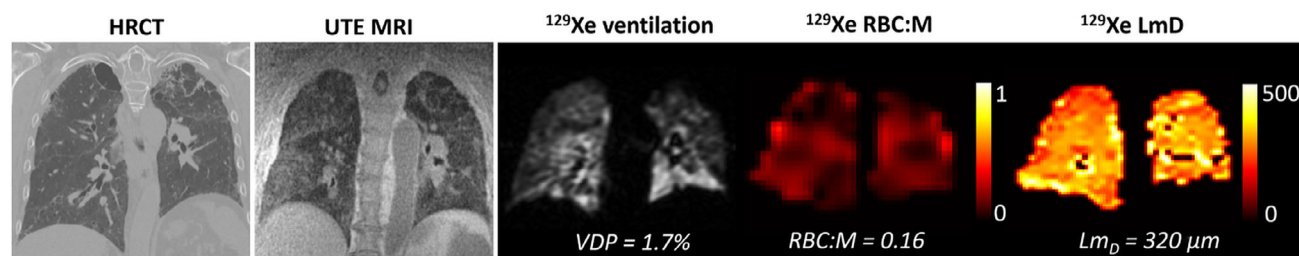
CT and MRI in long-COVID. Coronal images are shown for a 73-year-old male hospitalized due to COVID-19, with no prior respiratory disease. Left panel is chest CT acquired 6 months after hospital discharge with ground glass opacities, reticulation, and fibrotic-like changes. Next right panel is UTE MRI with similar findings. Middle and right panels show hyperpolarized ^{129}Xe MR ventilation, RBC:membrane map and diffusion-weighted map acquired 10 months after hospital discharge. HRCT = high resolution CT; RBC = red blood cell; VDP = ventilation defect percent; LmD = mean acinar airway dimension from diffusion-weighted map.
